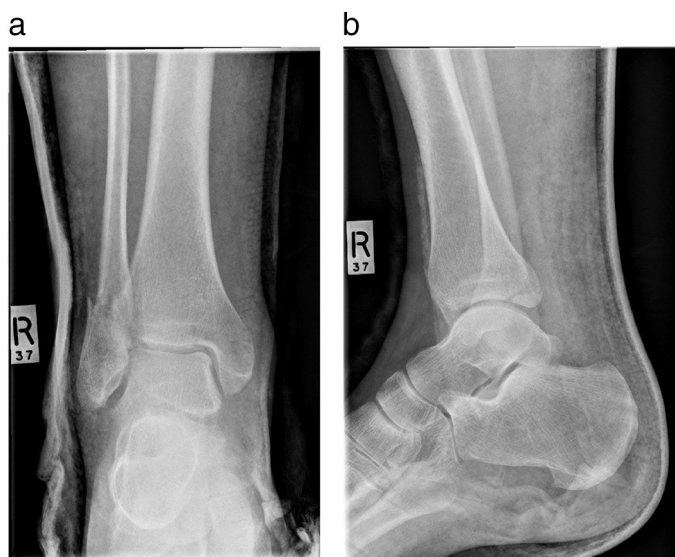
a: Anteroposterior radiograph of the right ankle dated 5 August 2006 showing a trimalleolar fracture.
